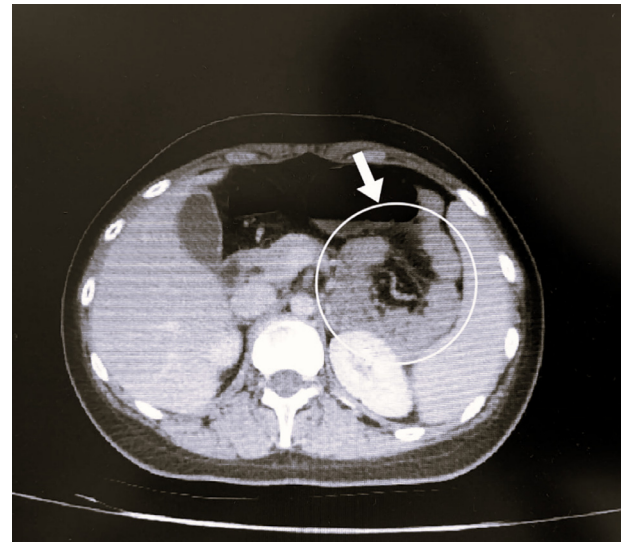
CT scan of the abdomen showing the presence of the proximal small bowel loops in the left upper quadrant in the lesser sac.
